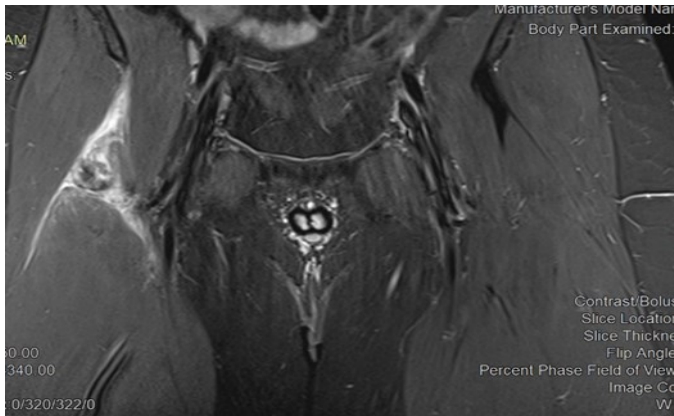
MRI pelvis, coronal cuts showed avulsion of right rectus femoris from origin.
